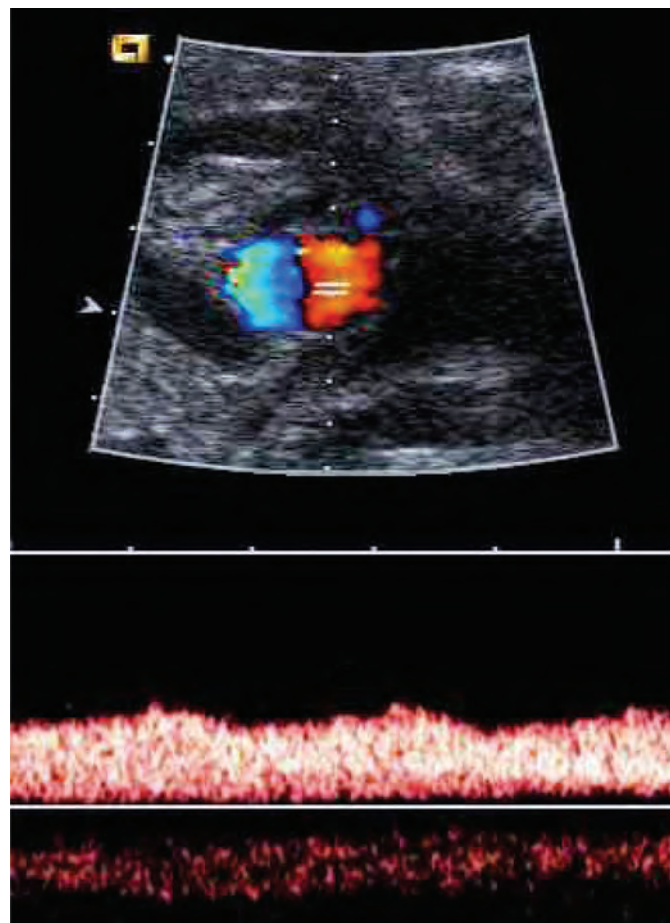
Umbilical vein aneurysm. Color Doppler ultrasound shows flow in this venous aneurysm.
